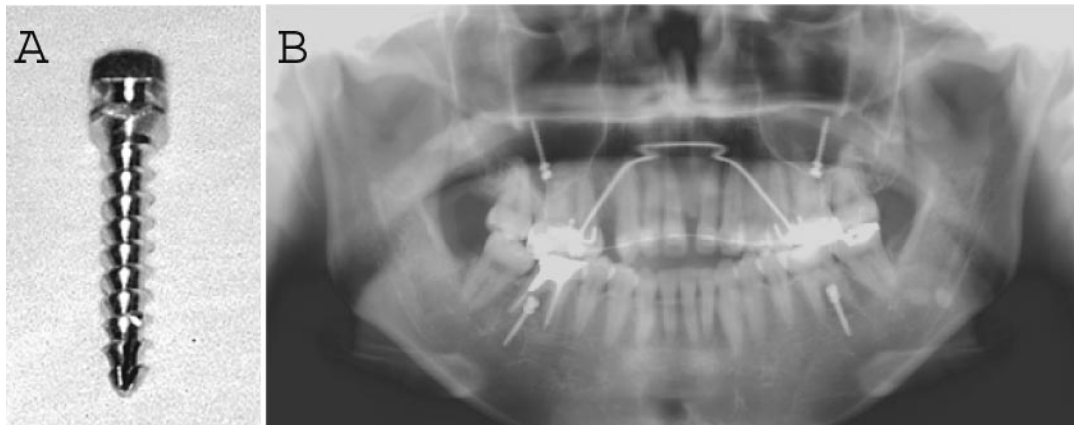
(A) Photograph of the titanium screw. (B) Panoramic radiograph after implantation of titanium screws.
